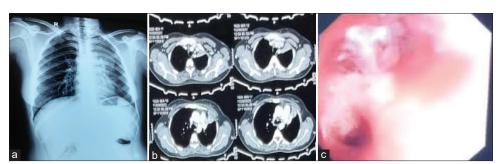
(a) Chest X-ray showing heterogenous opacity in the left mid lung zone, (b) CECT thorax shows heterogeneously enhancing soft tissue density in the left upper lobe of size $3 \times 3.9 \times 5$ cm with ipsilateral upper lobe collapse with enlarged para-aortic and mediastinal lymph nodes, (c) bronchoscopic image showing growth in the left upper lobe bronchus
